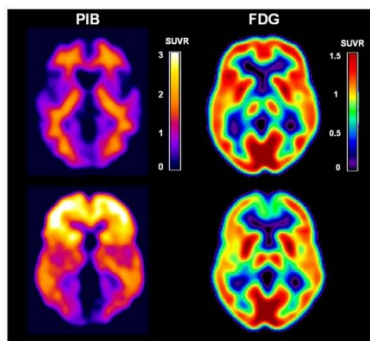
Pittsburgh Compound-B (PIB) and FDG-PET scans in two representative cognitively normal individuals: one at low risk for AD (top row: negative PIB and normal FDG uptake); and one at high risk for AD (bottom row: positive PIB and reduced FDG uptake) based on PET imaging findings. Cerebral-to-cerebellar PIB Standardized Uptake Value ratios (SUVR) are displayed for each modality using a colour coded scale. [Mosconi et al, 2010]. (Reproduced with permission).
